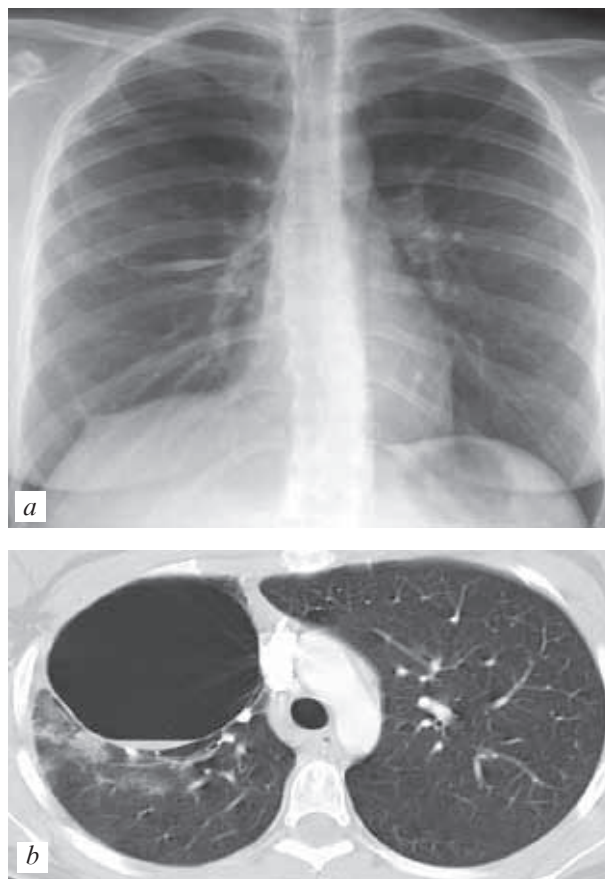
Right-sided intrapulmonary bronchogenic cyst (X-ray, CT) (a, b)
